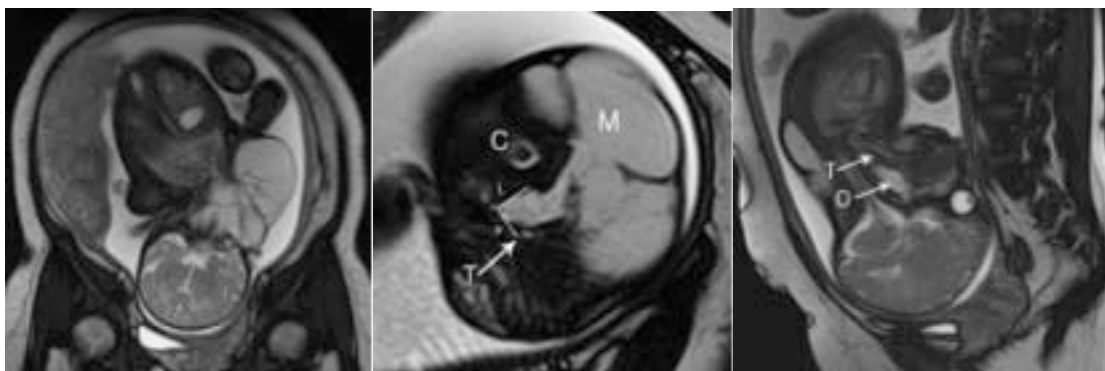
(a): Ultrafast MRI /ssfp coronal images of the fetus demonstrates cystic hygroma on the left side of the neck and right lateral flexion of the fetal neck. Note the placenta in the upper segment on the right lateral wall. (b) Ultrafast MRI /ssfp axial images of the fetus demonstrating the displacement of trachea(white arrow, T) by mass (M) and trachea-esophageal displacement index (TEDI). TEDI is defined on fetal MRI as sum of the lateral (L) and ventral (V) displacements (in millimeters) of tracheoesophageal complex (T) from its normal anatomical location at the ventral aspect of the cervical spine (c).
